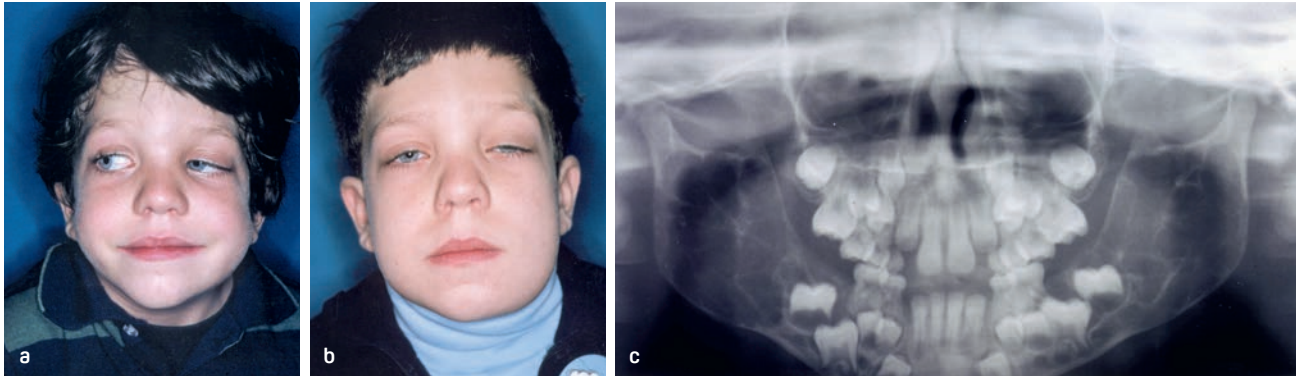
(a) Frontal photograph of a 5-year-old boy with cherubism. (b) Same patient at age 12. Note the progressive swelling of the cheeks and lower face. (c) Panoramic radiograph shows the large multilocular radiolucencies that occupy the body and ramus of the mandible.
